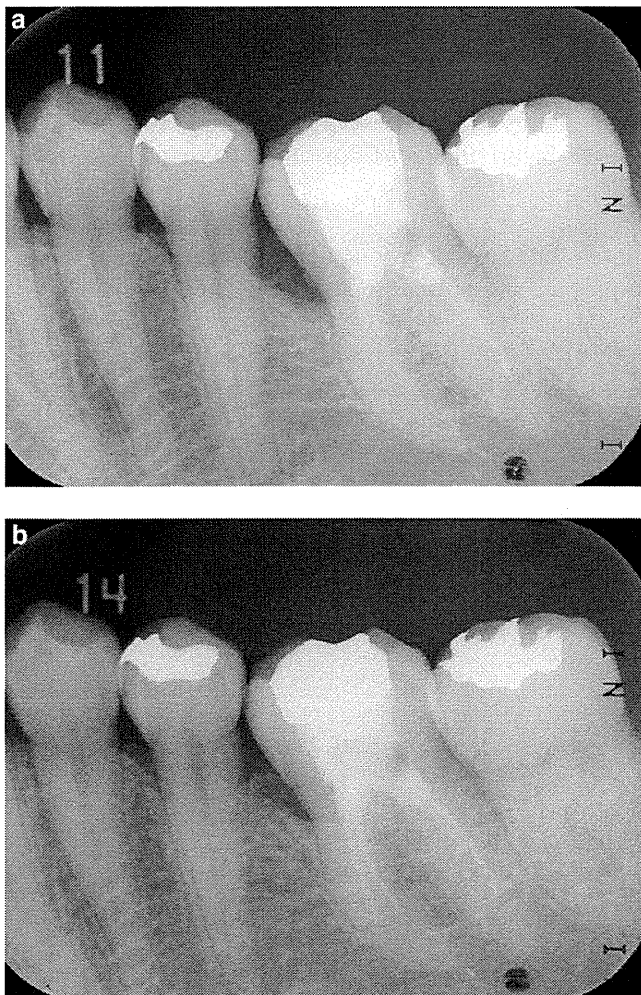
Case 2. Standardized dental radiograph before administration. 4b 36 weeks after administration of 0.3% FGF-2.
